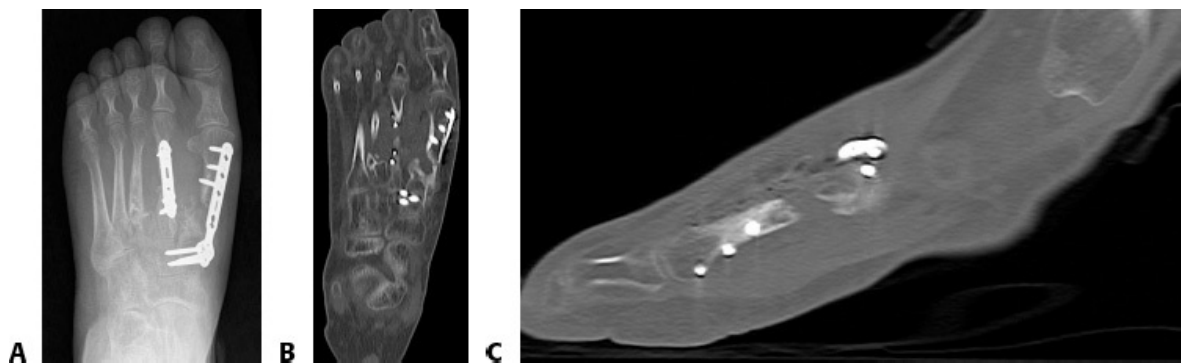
• A. Anteroposterior radiograph of nonunion of the first metatarsal. Axial (B) and sagittal (C) CT scans confirming the nonunion.
